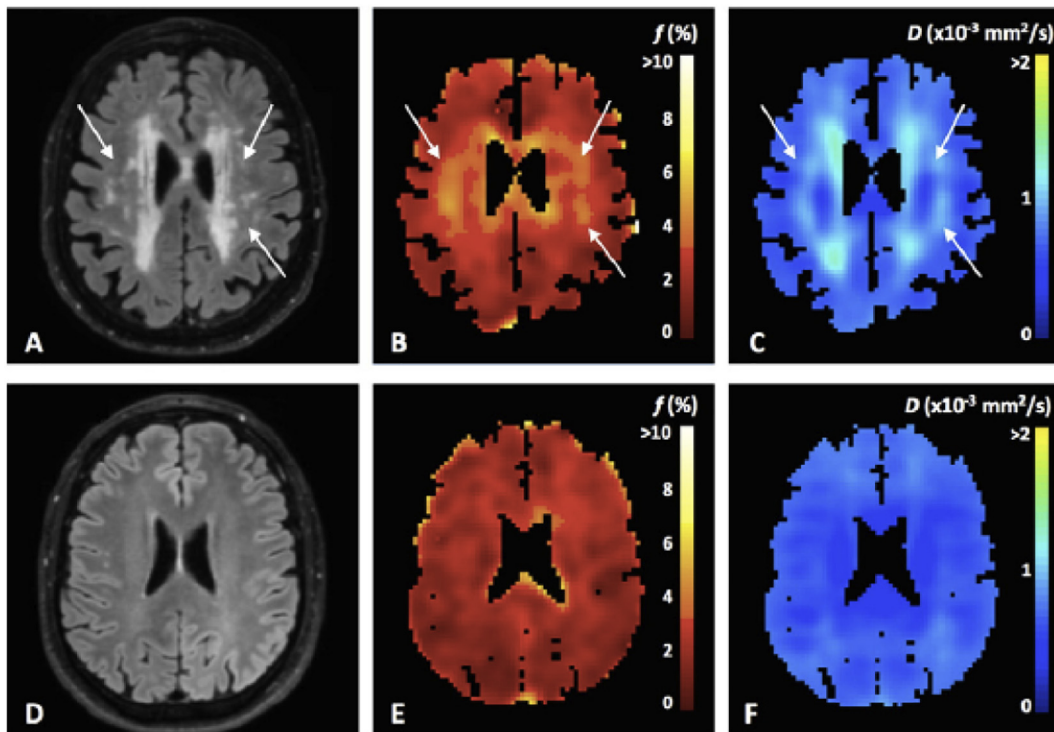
Example of FLAIR images (A, D), perfusion fraction f maps (B, E) and parenchymal diffusivity D (C, F) for a small vessel disease patient (top row) and a healthy subject (bottom row) (Wong et al., 2017).
